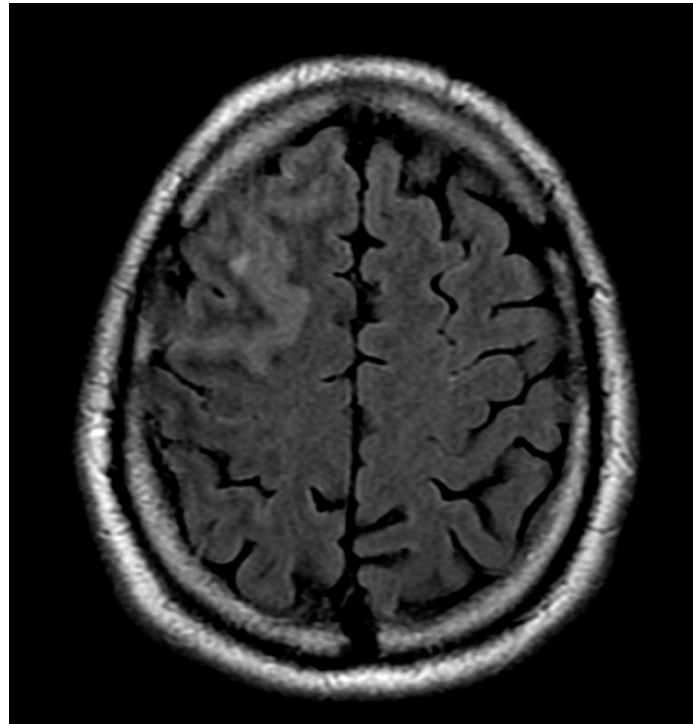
Brain MRI, axial FLAIR, revealing hypersignal and locoregional thickening of the superior frontal sulcus.
